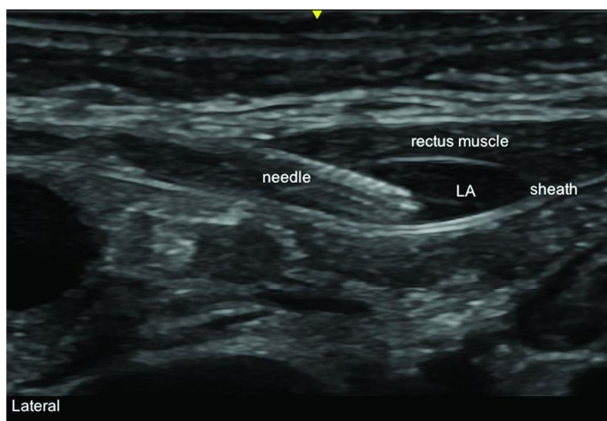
Ultrasound image of rectus sheath block in case one showing the needle and local anesthetic deposited.
